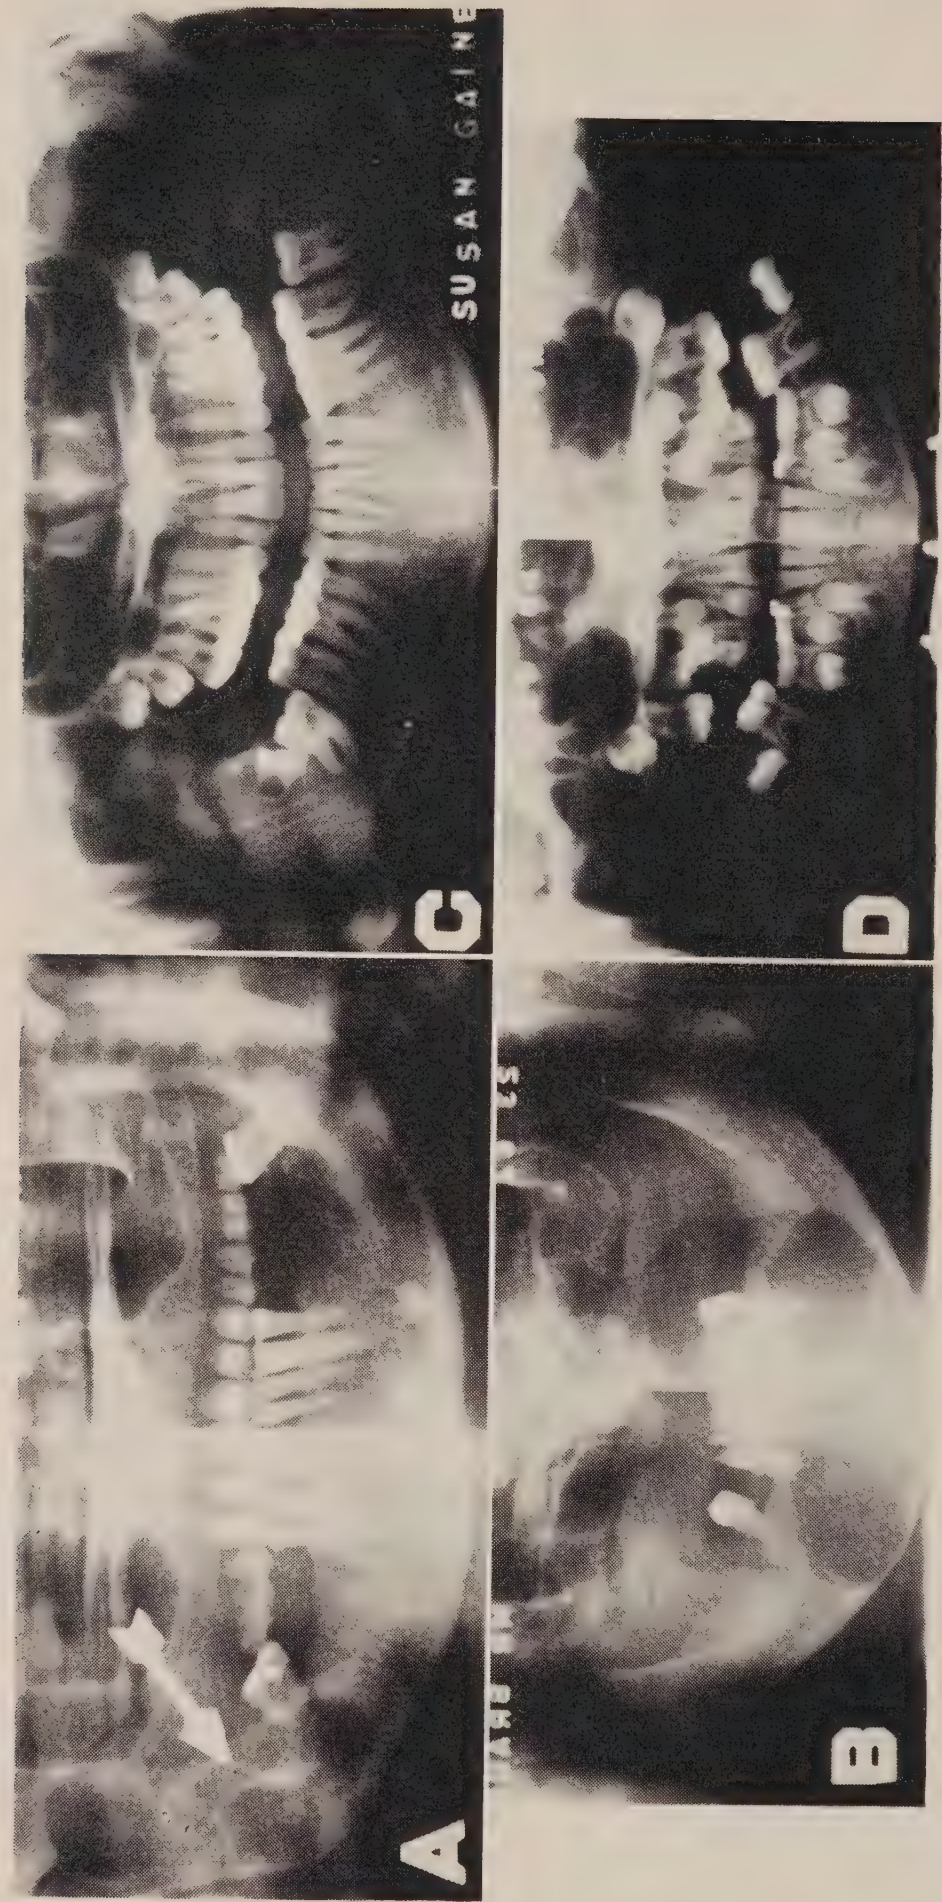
A, Ameloblastoma and B, extensive cyst extending from first molar to first bicuspid. C, Fourth molars appearing after four first bicuspids had been removed for orthodontic reasons. D, Ankylosis of second deciduous molars and ectopic eruption of upper left first molar causing early loss of contiguous second deciduous molar. This is an imminent serial extraction problem and can be recognized early with a panoramic radiograph.
